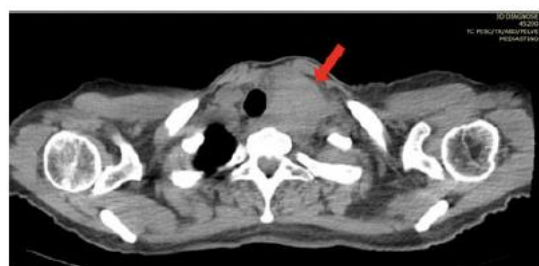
Computed tomography of the cervical region mass at the left base of the neck, heterogeneous, extending into the mediastinum, measuring 7.0×5.0×5.0 cm (red arrow).
